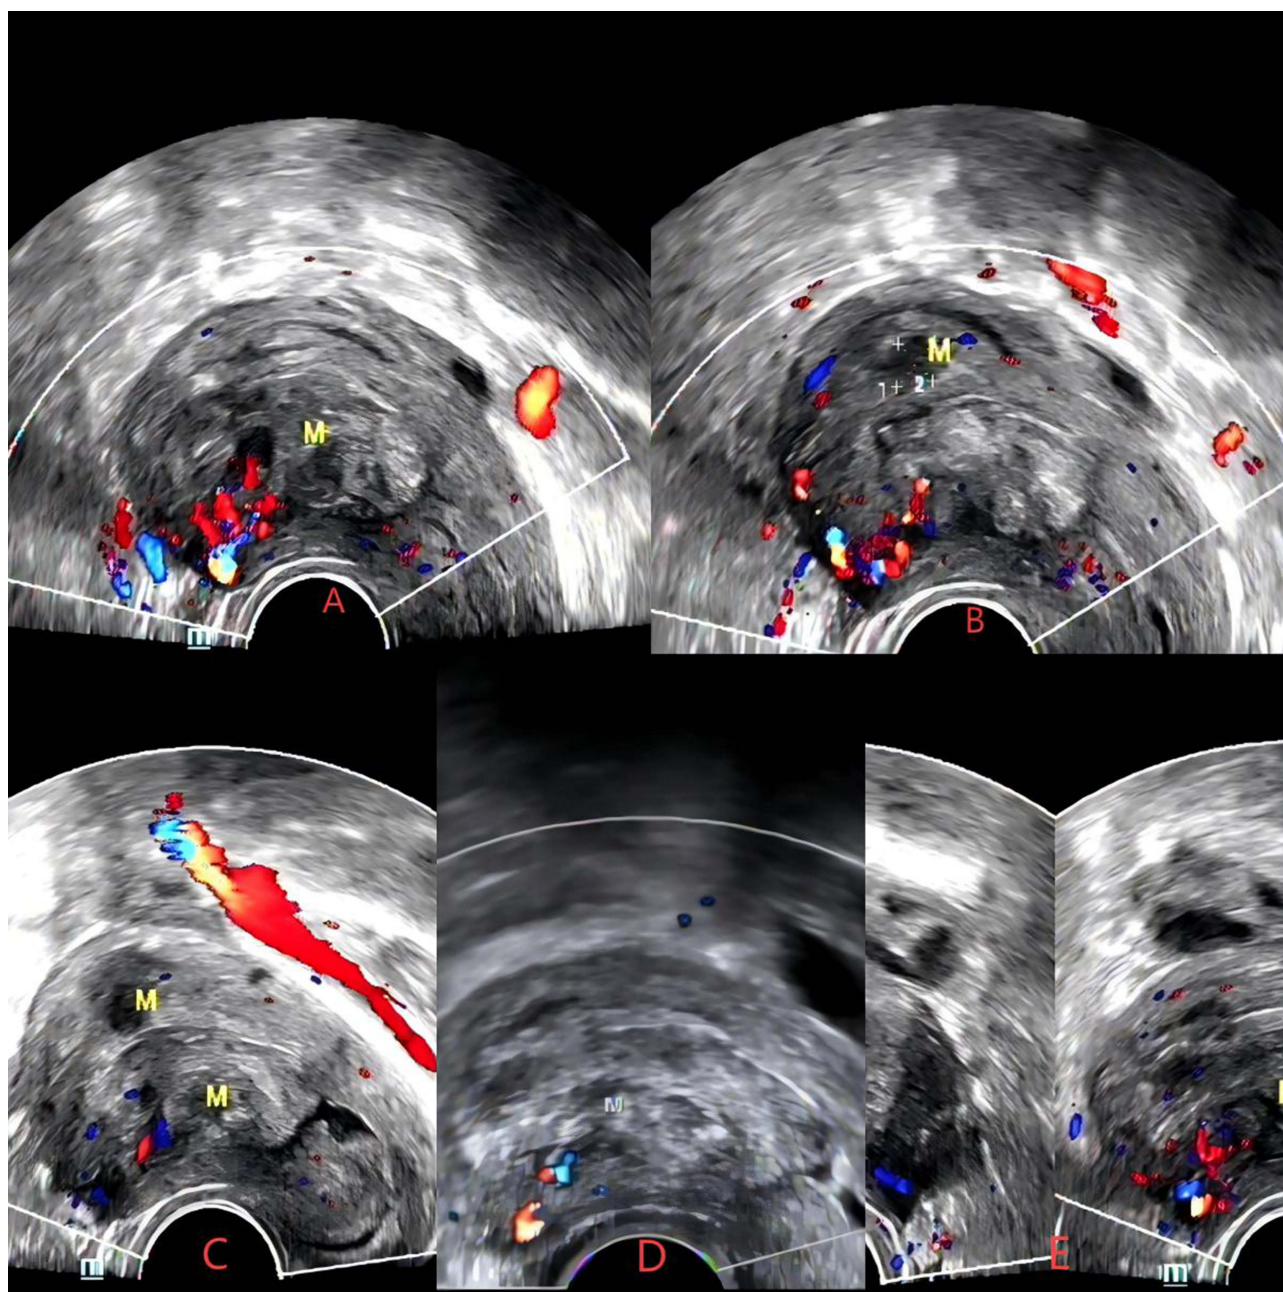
Ultrasound scan results of the uterus after one month of mifepristone treatment (A and B). The ultrasound scan results of the uterus after two months of mifepristone treatment (C, E). Ultrasound scan results of the uterus after three months of mifepristone treatment (D). The "M" in the Figure 3 represents a leiomyoma. According to the ultrasound results, the majority of the patient's submucosal myoma was located in the uterine cavity, and it was considered to be converted to type 0.
